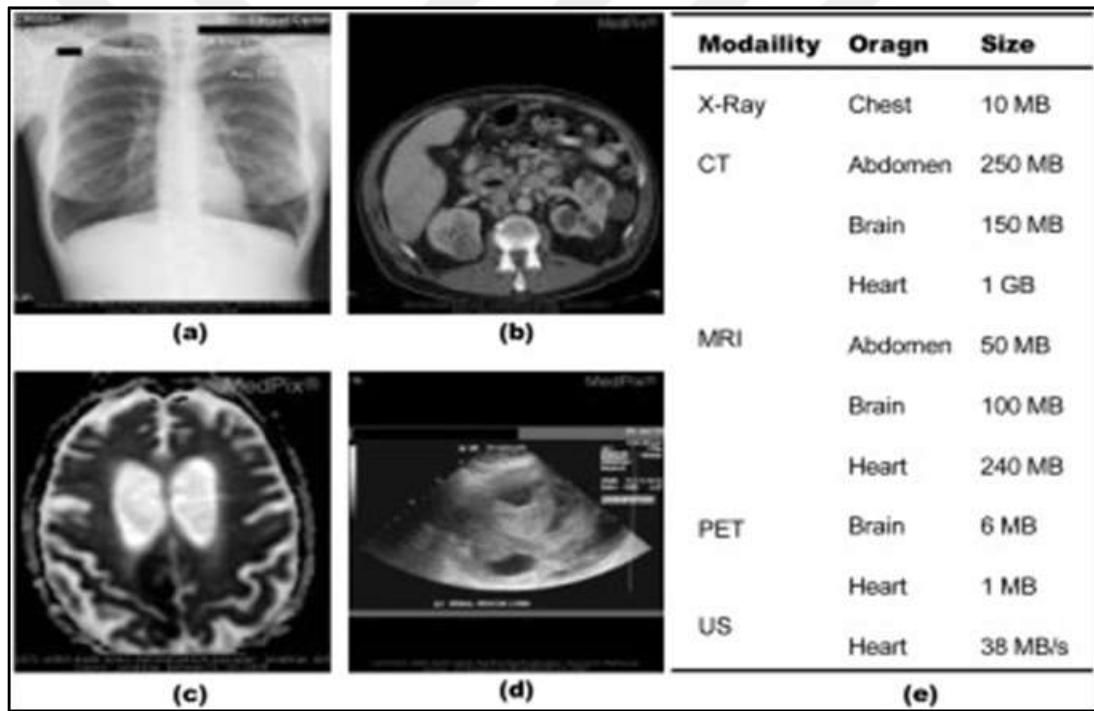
Radiological Imaging Modalities and Their Characteristics: X-ray (a), CT (b), MRI (c), Ultrasound (US) (d), and Image Attributes (e) [38].
